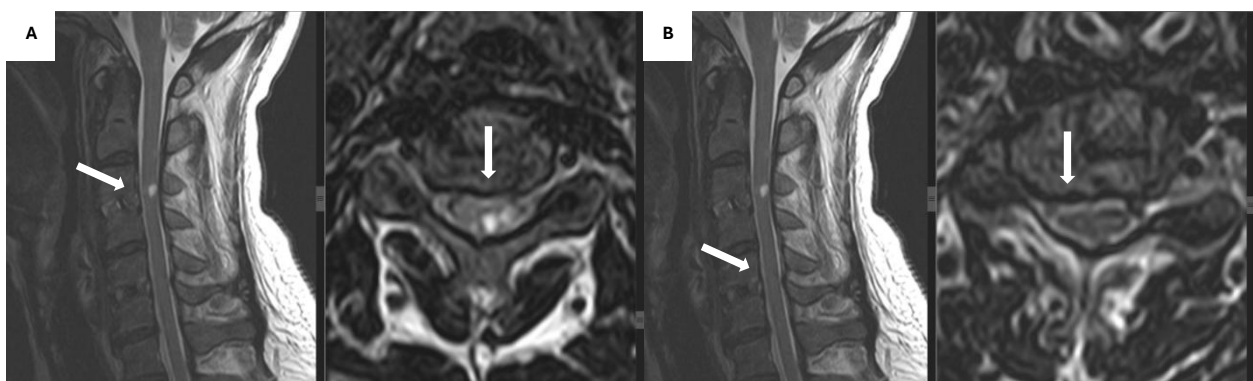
Postoperative follow-up: Non-contrast MRI of the cervical spine. (A). T2-weighted image of the C3-4 level showed cervical cage in good position with no compression of the spinal cord. There is myelopathy of the spinal cord (arrows). (B). T2-weighted image of the C5-6 level showed cervical cage in good position with no compression of the spinal cord. (arrows).
